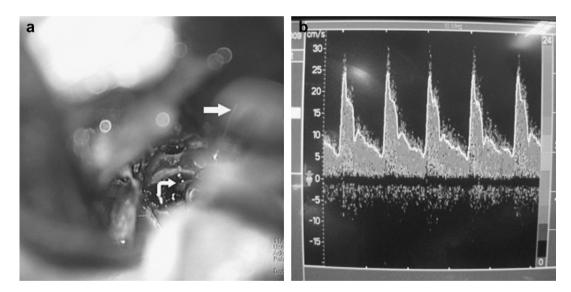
(a) 3 MHz Doppler probe (curved arrow) placed on dural surface, held between the cusps of a biopsy forceps (straight arrow); (b) Initial Doppler trace of the ICA at a depth of 3 mm.
